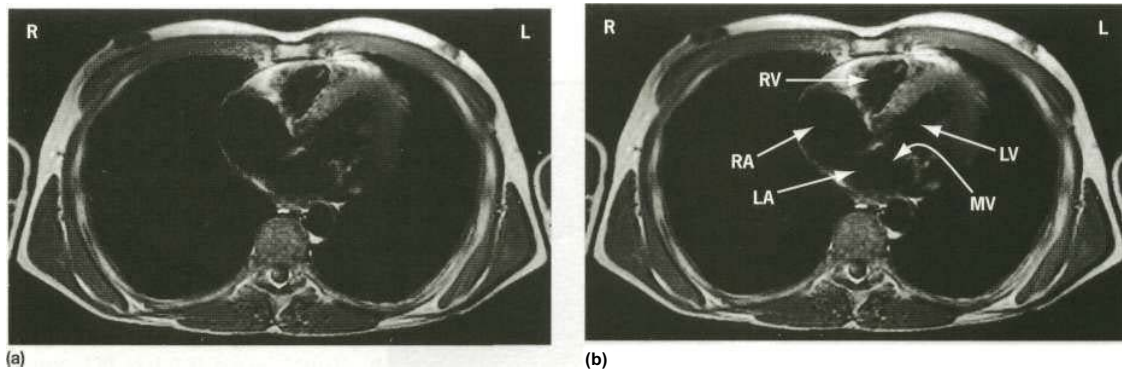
Magnetic resonance image (MRI), showing a pair of axial images taken through the mid-thorax at the level of the mitral valve, (a) A view of end-systole, (b) Taken at end-diastole. Note the clear differentiation between the atria and ventricles. This is a normal study. LA, left atrium; LV, left ventricle; MV, mitral valve; RA, right atrium; RV, right ventricle.
